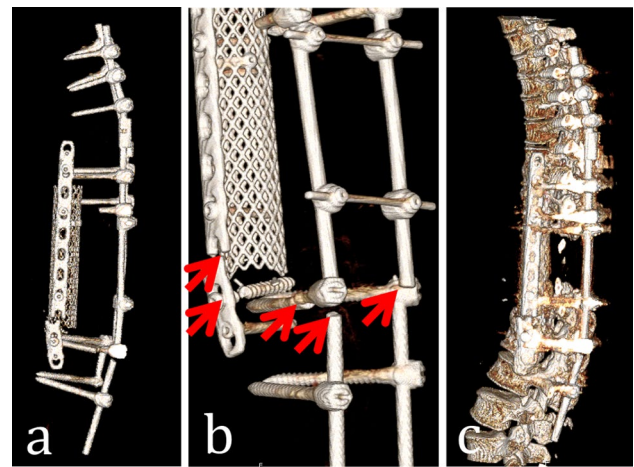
F/u 04/2015 3D CT scan of the spine. A situation after anterior–posterior stabilization during the 2015 control. The patient has back pain. Red arrows: indicating the location of implant failure, a lateral view on the 3D spin. Only the implants are shown. Distal screws, bars and the plate are broken, b detailed view in the implant failure, the distal part is fully separated from the proximal part, and c implants are shown in relation to the spine
